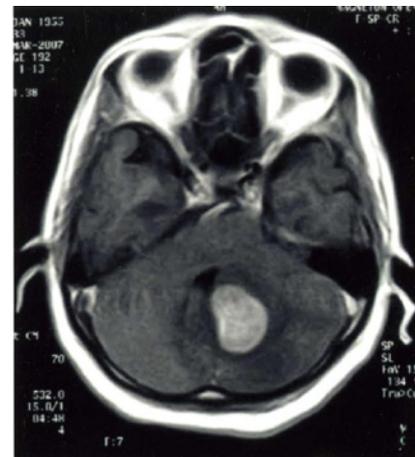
CT Scan of brain showing Lt. Cerebellar space occupying lesion.
